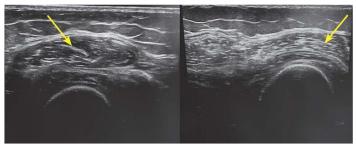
Ultrasound diagnostics of the rectus femoris muscle on the left and right (indicated by arrows) of patient L., 53 years old. Consequences of stroke. The side of the brain injury is left. Changes are visualized in the echogenicity of the muscle fiber, its thickness mainly in the side opposite to the side of the brain injury
